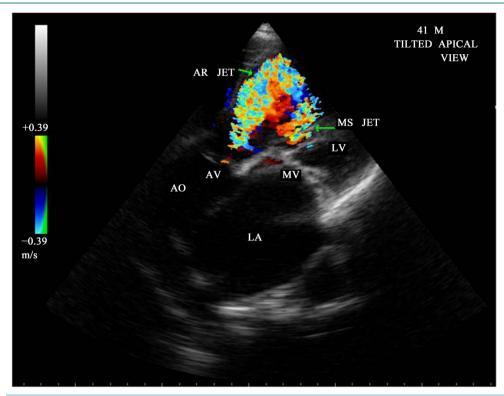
CW doppler showing the MS jet and AR jet in tilted apical view.
